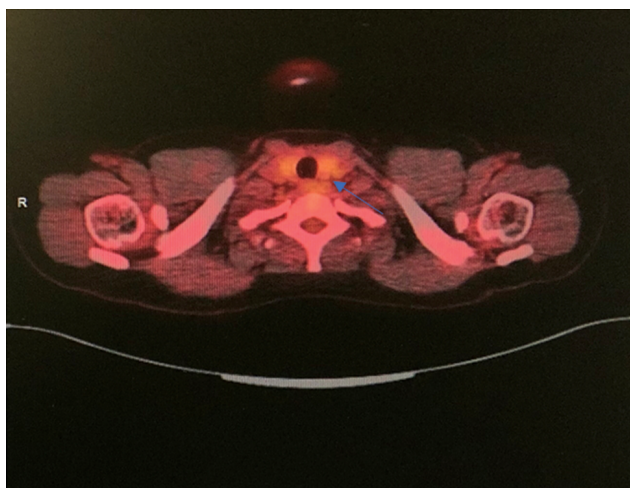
Hybrid axial PET/CT image - a lesion located dorsally of the left thyroid lobe is visualized with low metabolic activity, SUVmax - 2.00 which is suspected for a parathyroid adenoma.
